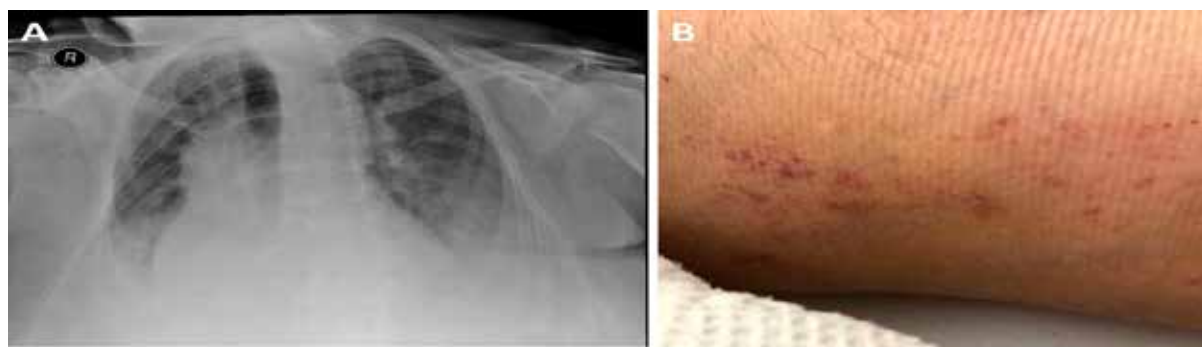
Chest X-ray showing bilateral diffuse basal pulmonary infiltrates (A). Petechial rash on the patients' inner thighs (B).
